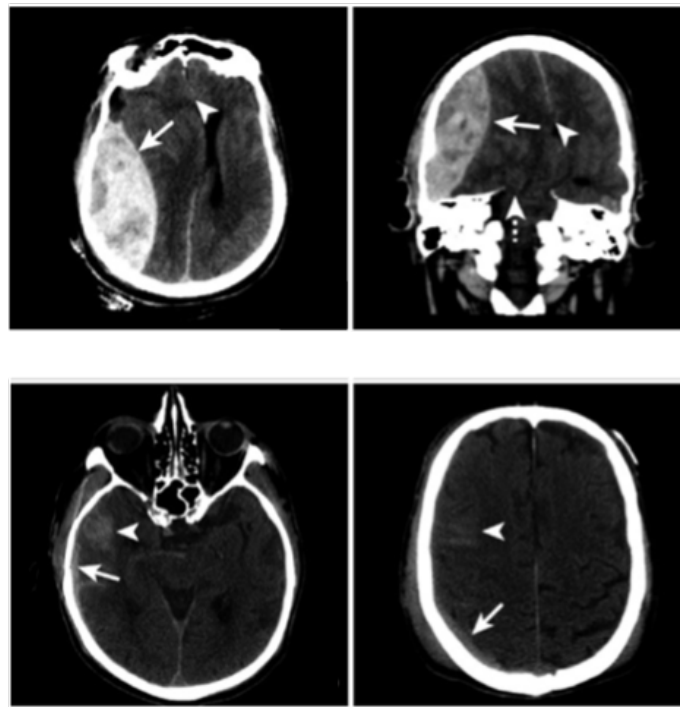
Non-Contrast CT images of ICH. Top row images show an epidural hematoma in the right cerebral hemisphere resulting in leftward mid-line shift. Bottom row images show a subdural hematoma in the right cerebral hemisphere [29].
